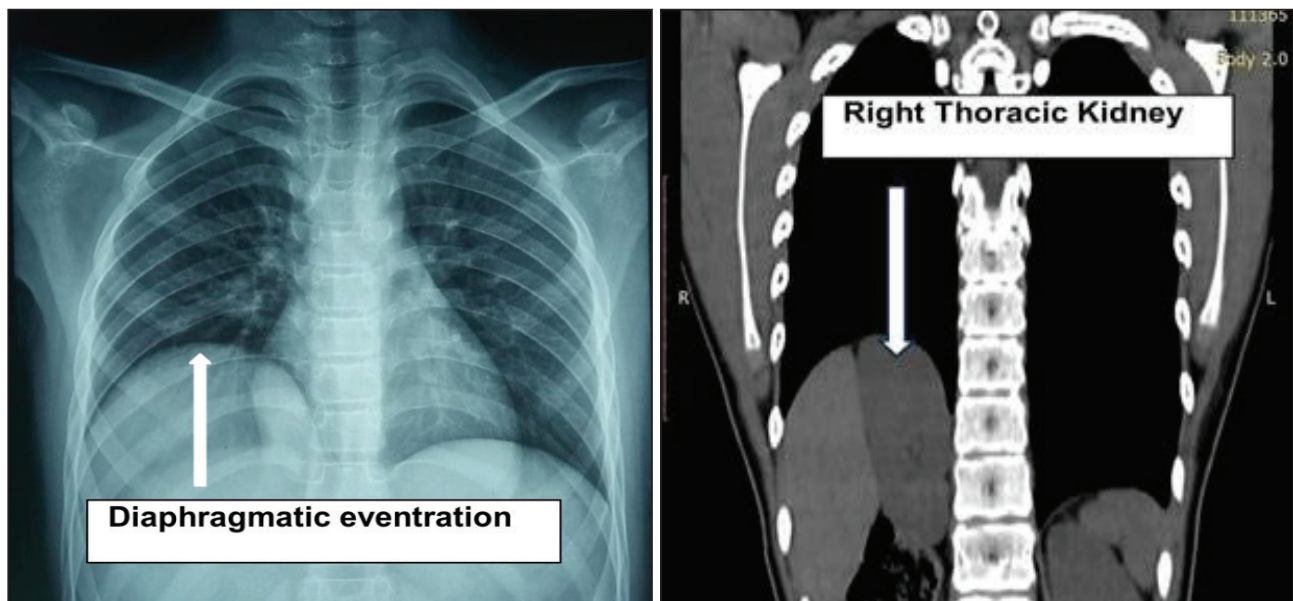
Chest X-ray showing right-sided diaphragmatic eventration, and coronal CT scan images showing right thoracic kidney.
